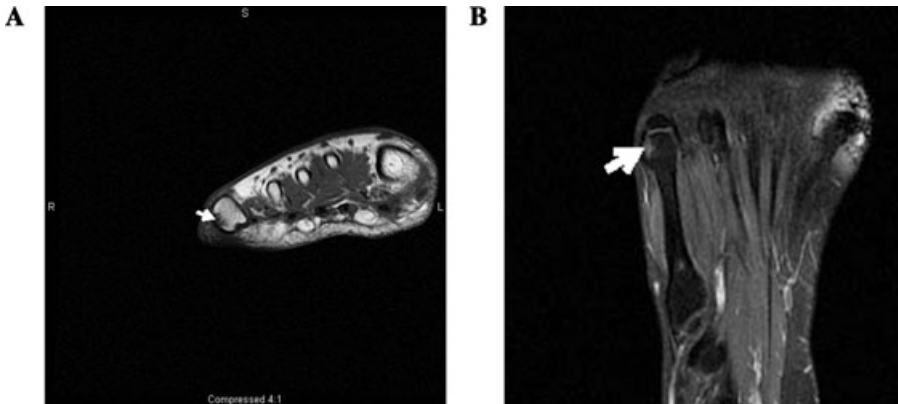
MRI was performed on a woman with a diagnosis of RA and pain in her 3rd through 5th toes. Coronal T1 (A) and axial T1-weighted images with fat saturation and gadolinium contrast administration (B) were taken. These images reveal an erosion at the lateral aspect of the 5th metatarsal head that is low signal on the T1-weighted images and enhances after gadolinium administration (white arrows).
